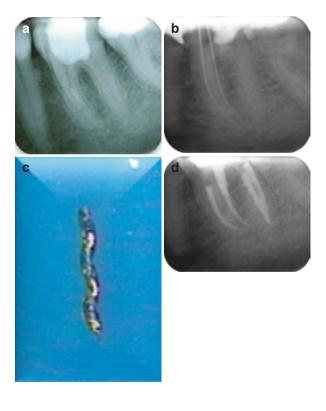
(a) Fractured instrument in the mesiolingual root canal. (b, c) Control radiograph following removal of the fragment. (d) The radiographic control reveals massive loss of dental hard tissue in the coronal part of the root canal
